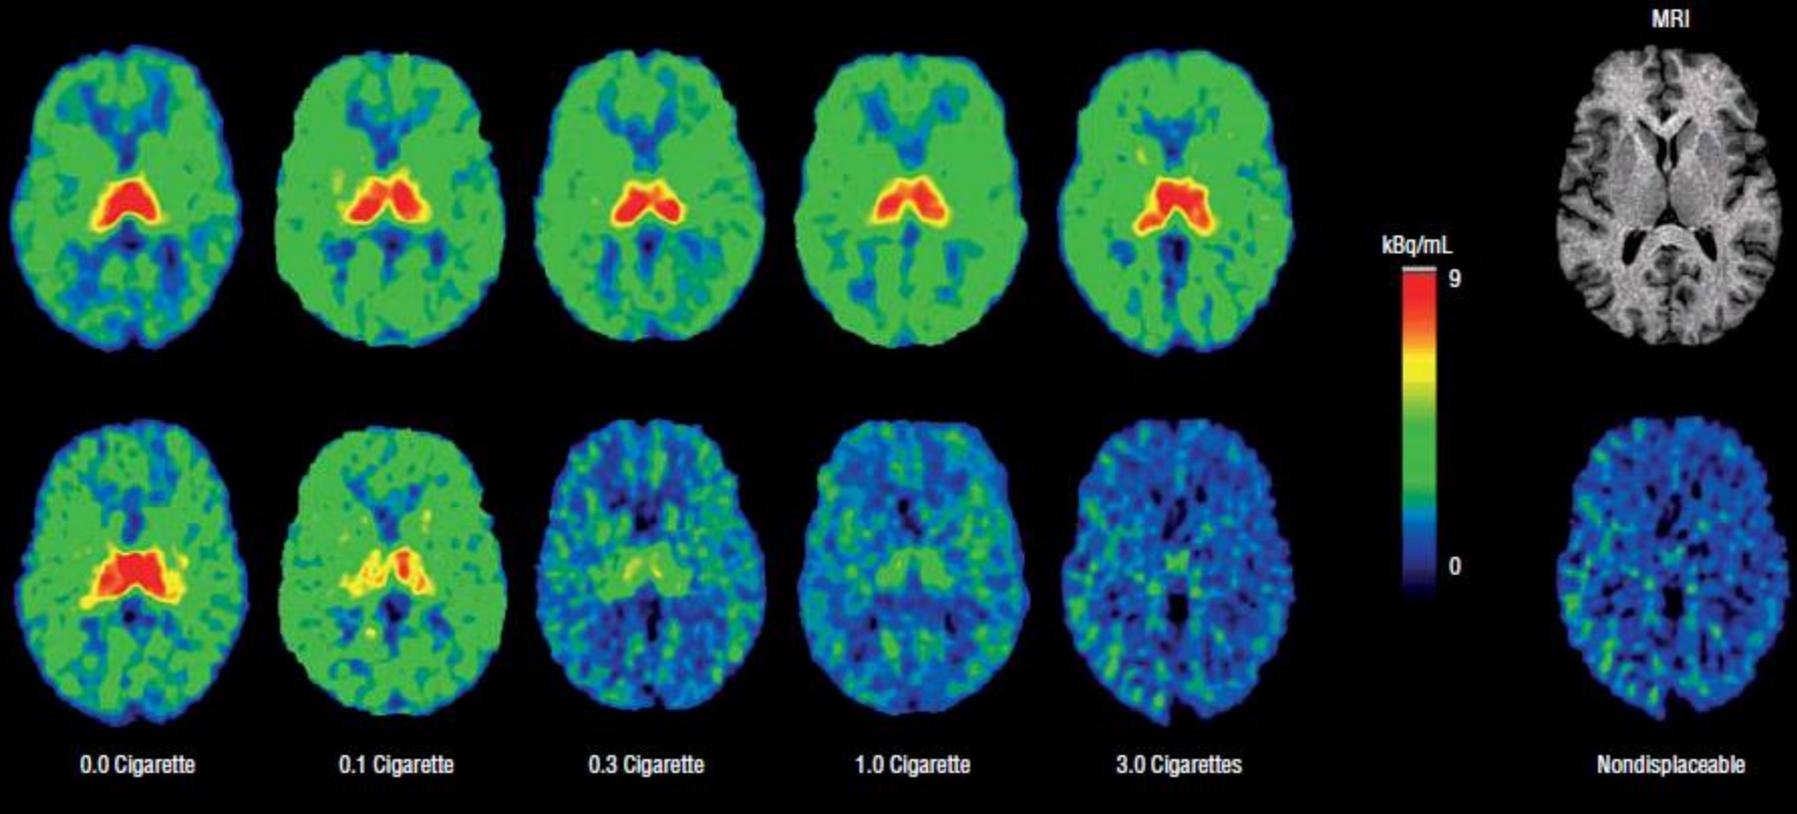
2-[¹⁸F]fluoro-3-(2(*S*)-azetidylmethoxy) pyridine (2-F-A-85380) positron emission tomography (PET) images before (top row) and 3.1 hours after (bottom row) cigarette smoking. Images were obtained by averaging the six 10-minute frames over the 1 hour prior to the smoking break and by averaging the seven 10-minute scans from a mean of 3.1 hours after smoking the cigarette amount listed. The far right column shows a magnetic resonance image (MRI) of the brain and a PET image of nondisplaceable radioactivity distribution (calculated). All PET images were aligned to the level shown on the MRI.
